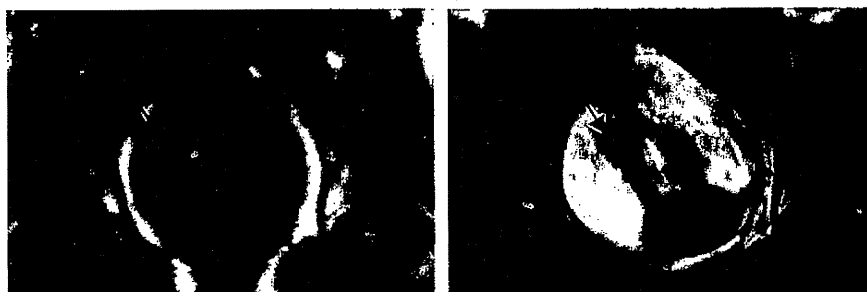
a: Pelvic MRI (T1 weighted image) showed a high intensity mass.
